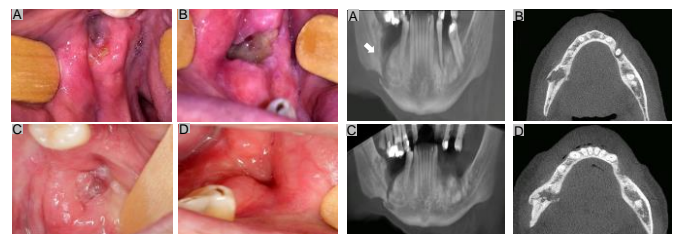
A and B. Bilateral exposed necrotic bone at initial consultation. C and D. Complete mucosal healing after 24 months of therapy. Figure 2. A and B. Initial presentation of a bilateral ill-defined lytic lesion in the mandibular body, and pathological fracture (arrow) in the right mandibular body. C. Lack of radiographic alteration after 24 months of treatment. D. Evidence of small bone formation in the fractured area.
